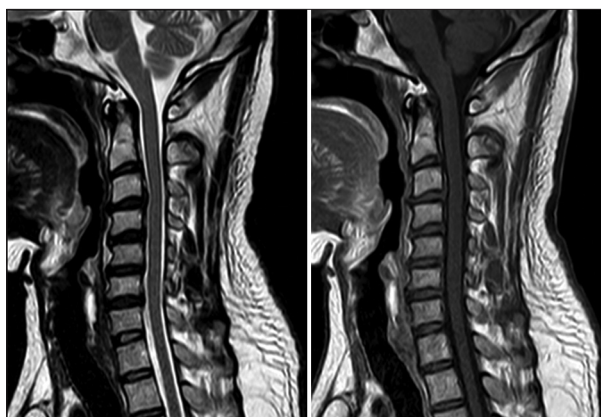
Magnetic resonance imaging cervical spine demonstrating no demyelinating, inflammatory, or compressive lesion
